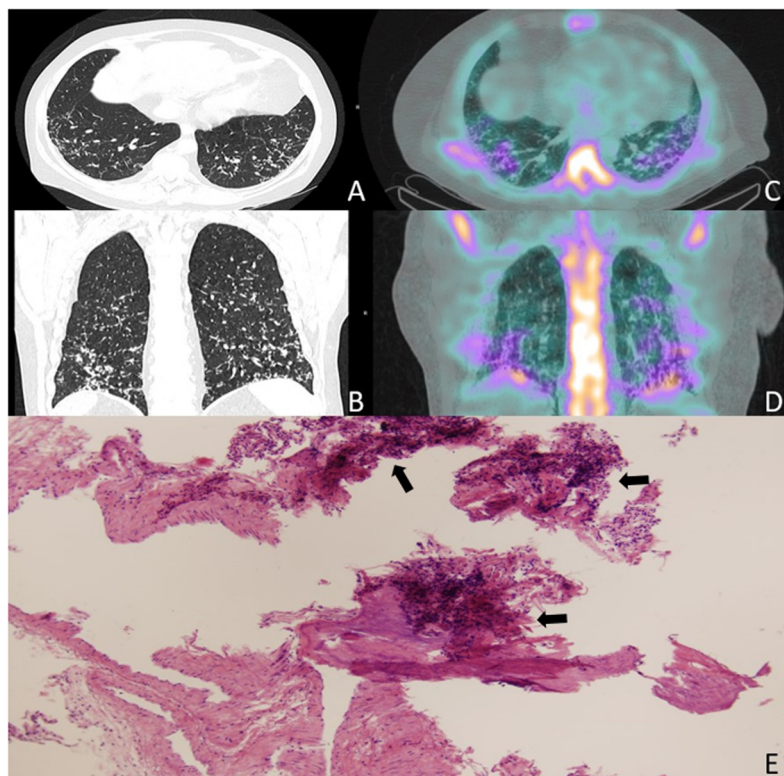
(A and B) Chest CT scan showing bilateral micronodular calcifications predominantly in the lower lobes. (C and D) Scintigraphy with Tc99m-HDP showing increased radiotracer uptake in the posterior basal segments of both lower lobes. (E) Pathology: fragments of lung parenchyma and stroma with a focus of calcification (indicated with arrows).
